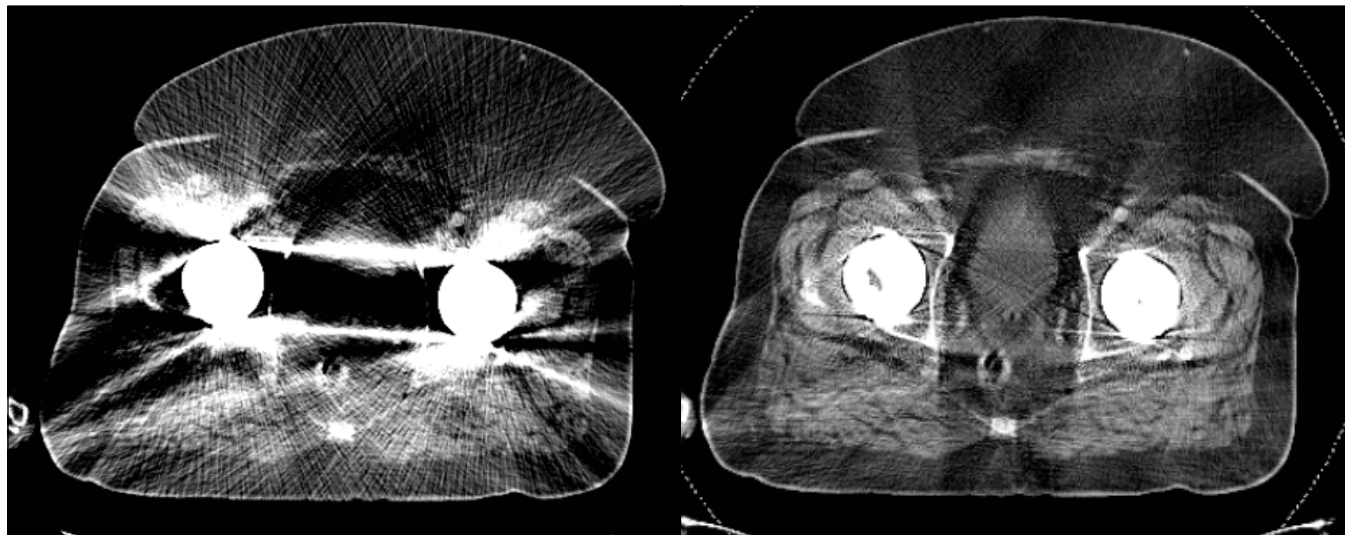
Axial appearances of the pelvis before (left) and after (right) the dual-energy CT artefact removal technique, with significantly clearer images of the bladder and bowel when artefact from the metallic hips is removed.
